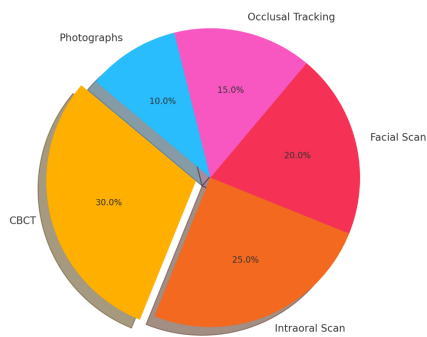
visualizes the typical proportional contribution of each data modality in orthodontic multimodal fusion. CBCT and intraoral scans form the backbone of skeletal and dental modeling, while facial scans, occlusal motion tracking, and photographic records enhance esthetic and functional evaluation.
